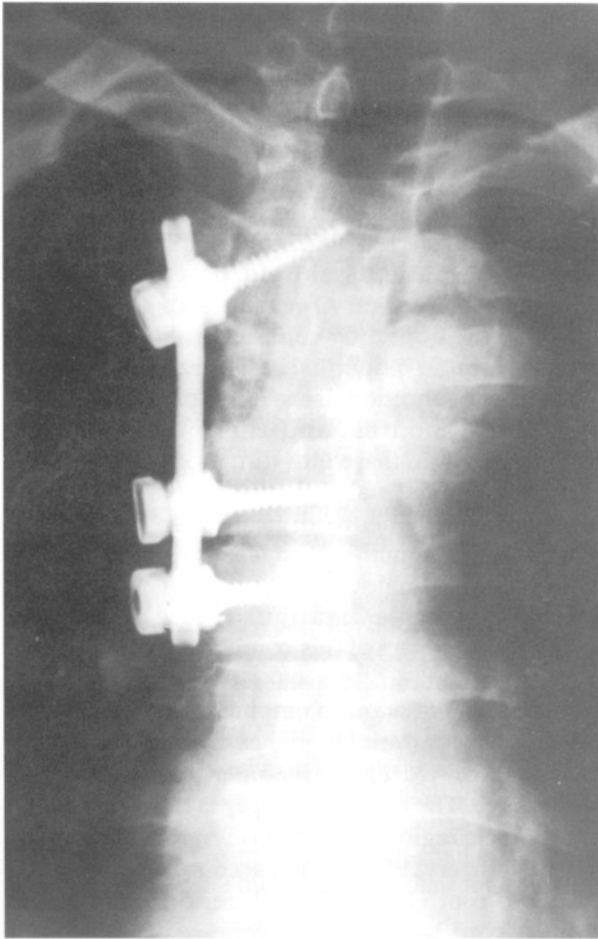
Anteroposterior roentgenogram obtained 44 months postoperatively, shows stabilization of the vertebral column achieved with s SVBS-rod fixation system. Note that the upper screw is angled approximately 40 degrees superiorly.
